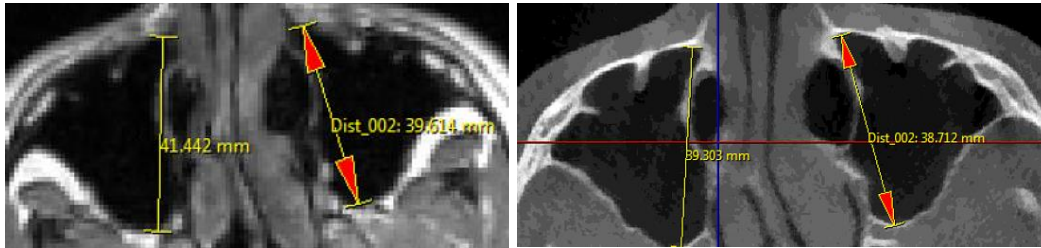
Measurement of the length of the maxillary sinuses. Shown here are right and left maxillary sinuses on CBCT slice (right) and MRI slice (left).
